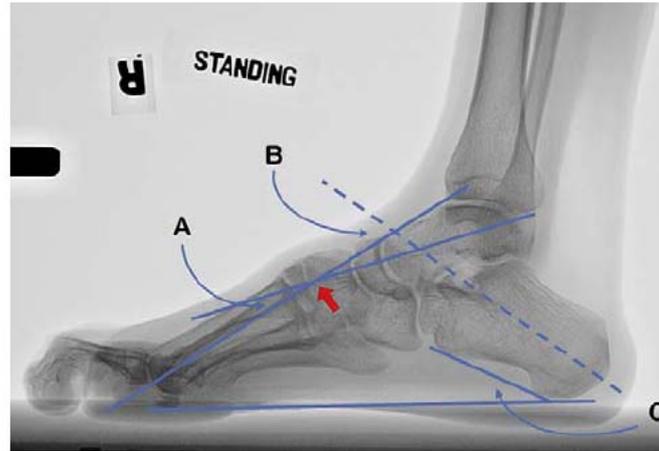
Radiographic angles as measured on a standing lateral radiograph of an adolescent boy with Charcot-Marie-tooth. (A) Meary's angle, formed by the intersection of lines drawn through the longitudinal axes of the first metatarsal and talus (normal is between 0° and 5° , cavus greater than 5°). (B) Hibb's angle, formed by the intersection of lines drawn through the longitudinal axes of the first metatarsal and the calcaneus (normal less than 45° , cavus greater than 45° and typically 90°). (C) Calcaneal pitch angle, formed by the intersection of a line parallel to the floor and another line drawn along the plantar surface of the calcaneus from the tuber to the anterior process (calcaneocavus greater than 30° , forefoot cavus less than 30°).
